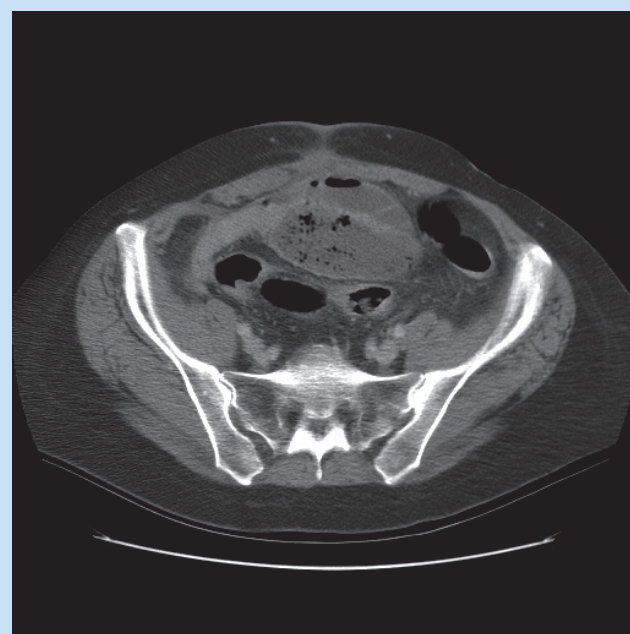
Axial CT in a 22-year-old female patient with history of Crohn disease demonstrating the small bowel faeces sign in a distended ileal loop. Adjacent transition zone with collapsed distal small bowel is seen.
